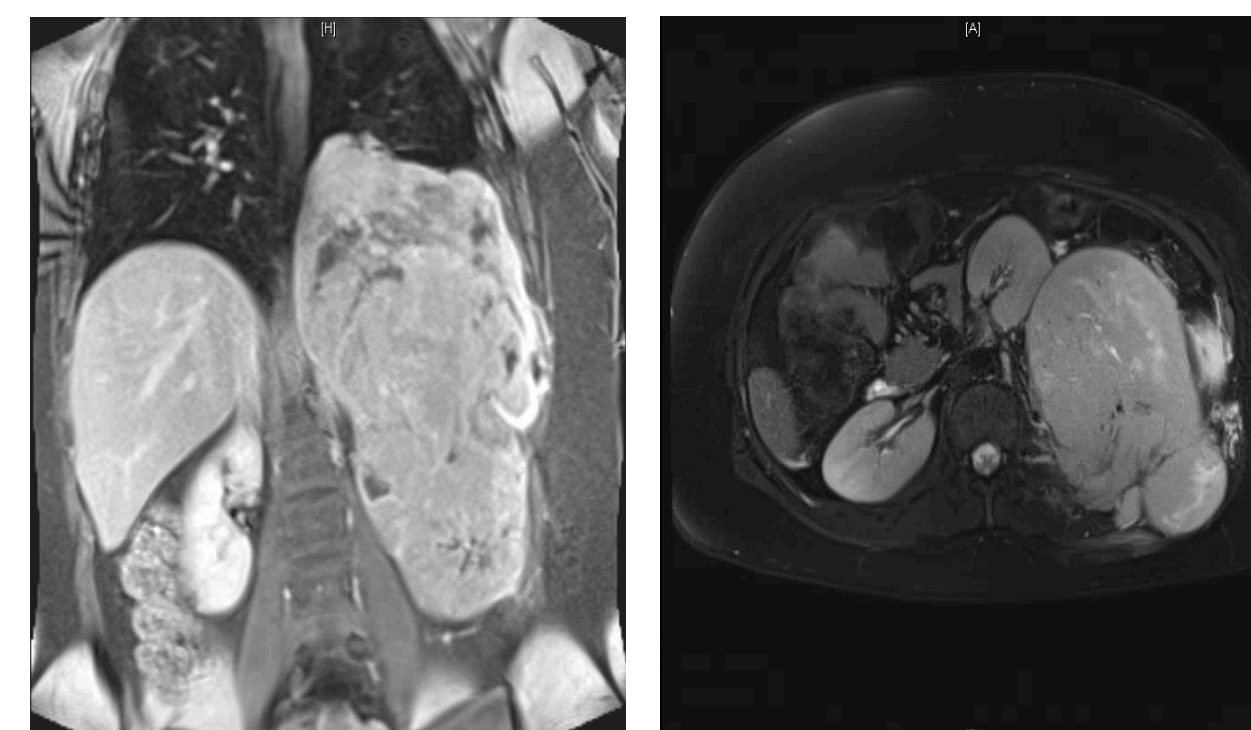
MRI of the chest. Mass invades the posterior aspect of the chest wall and displaces the left kidney and spleen anteriorly.
